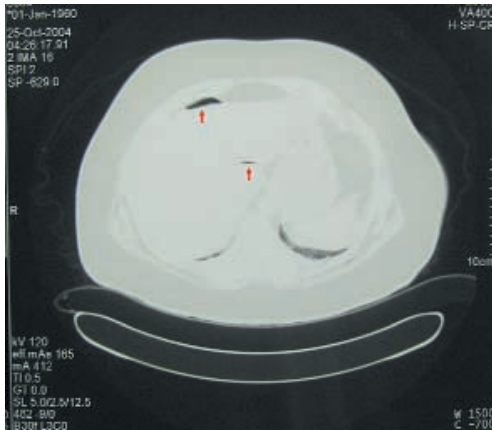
Air collection after gastrointestinal perforation (CT window for lung parenchyma).
